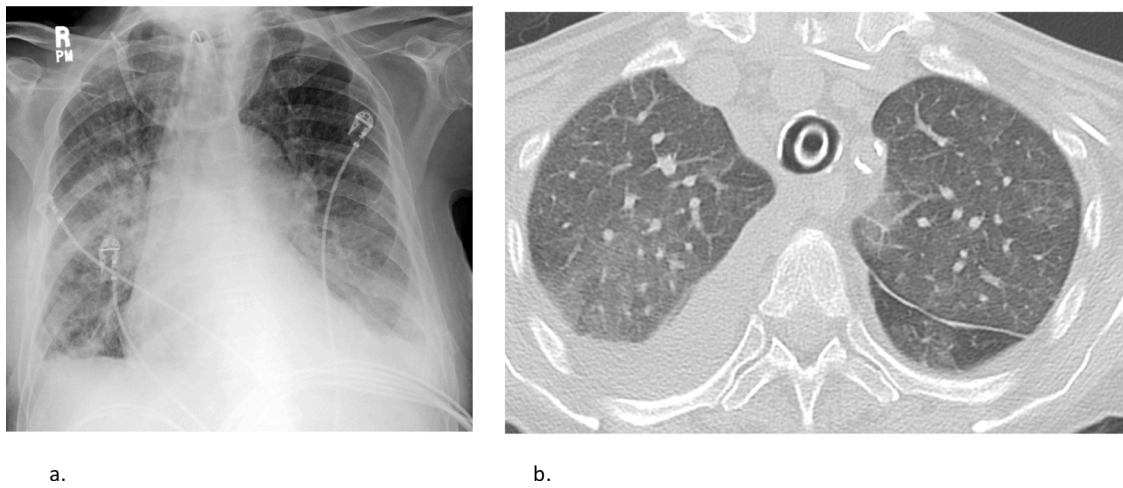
(a) 75 yo M with acute decompensated heart failure with CXR demonstrating cardiomegaly, perihilar opacities and septal thickening with small effusions. (b) CT performed the following day shows ground glass opacities, septal thickening, and increasing pleural effusions, right greater than left.
